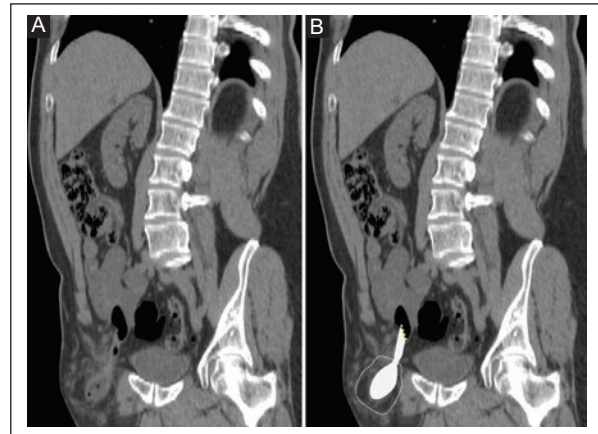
Oblique reconstruction of an abdomino pelvic CT image in simple phase of a 59-year-old male patient. A-B: femoral hernia that showing union of ileum and Meckel's diverticulum (yellow dotted line) depending on the anti-mesenteric border with a downward path inferior to the inguinal ligament into the hernia sac (white dotted circle). The diagnosis of a true Littre's hernia was made.
